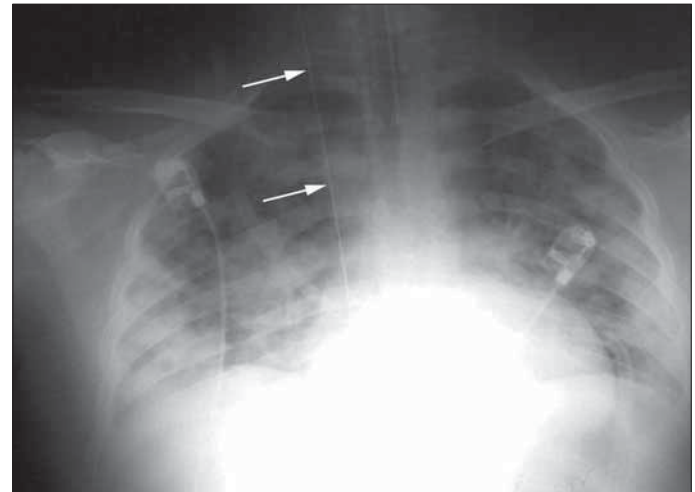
Chest X-ray shows the guide wire in the right internal jugular vein (Arrows point to the guide wire)
